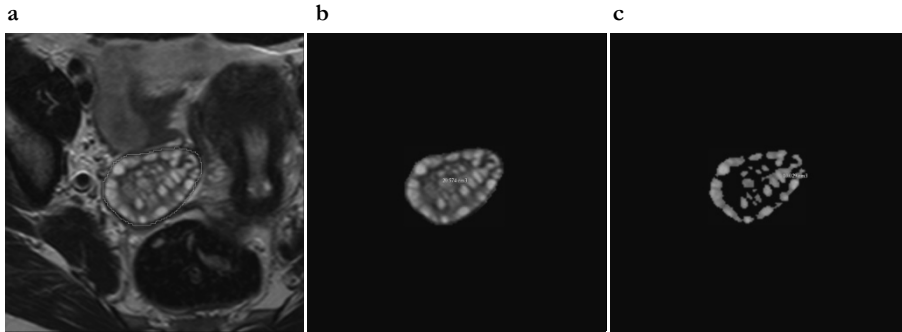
T2-weighted MRI scan in the transaxial plane. The outer border of the polycystic ovary is manually outlined in (a). This is completed in every section of the ovary visible, and the computer software “dissects” it from the surrounding tissue and calculates the total volume (b). By manually adjusting the threshold limit of signal intensity, fluid filled follicles are maximally projected and total follicle volume can be estimated (c).
